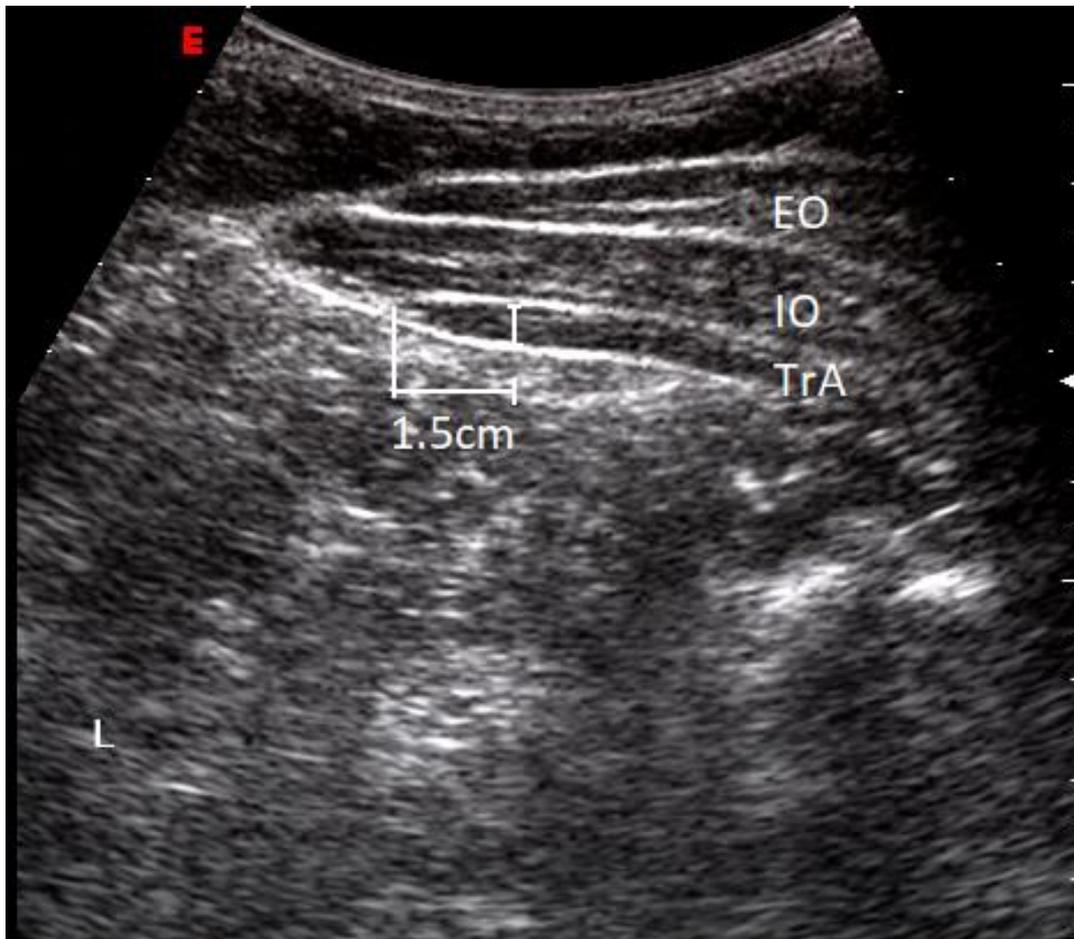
shows an ultrasound image of the TrA thickness measurement technique showing the hyperechoic fascial lines between each muscle. TrA- Transversus Abdominis, IO = Internal Oblique, EO = External Oblique
